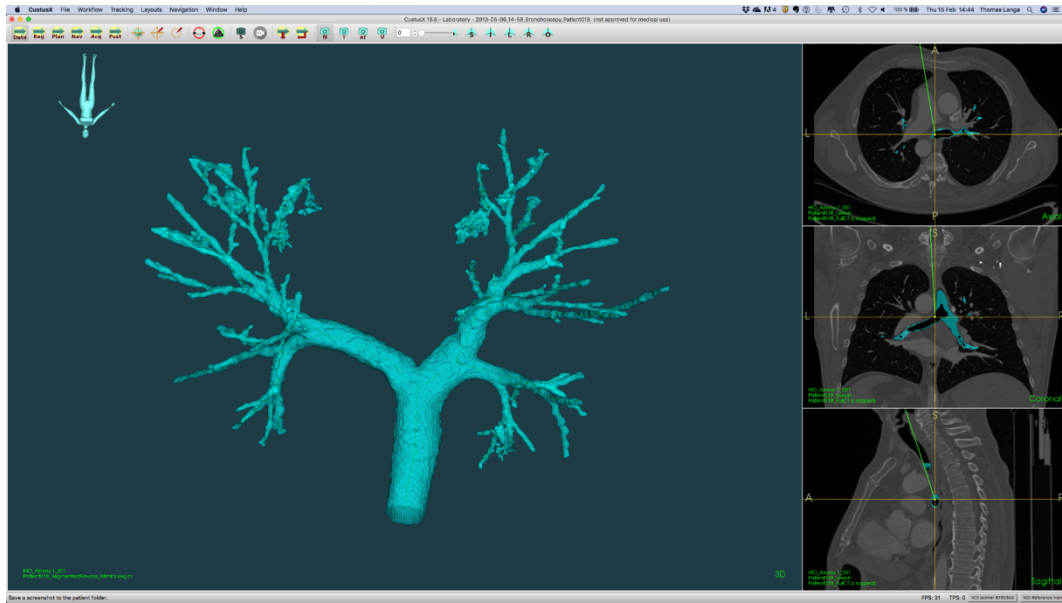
Navigation platform/system monitors display examples from the CustusX navigated bronchoscopy environment using a segmented 3D airway model (top left and bottom left) processed from preoperative patient CT (www.custusx.org) (13). Virtual bronchoscopy (bottom right) and axial, sagittal and coronal displays (top right) are available. Segmented models from the CT can be overlaid the orthogonal CT planes as shown and the centerline is extracted automatically with the airway lumen. Path to target is calculated automatically after defining the target manually (example: blue tumour in bottom left image).
